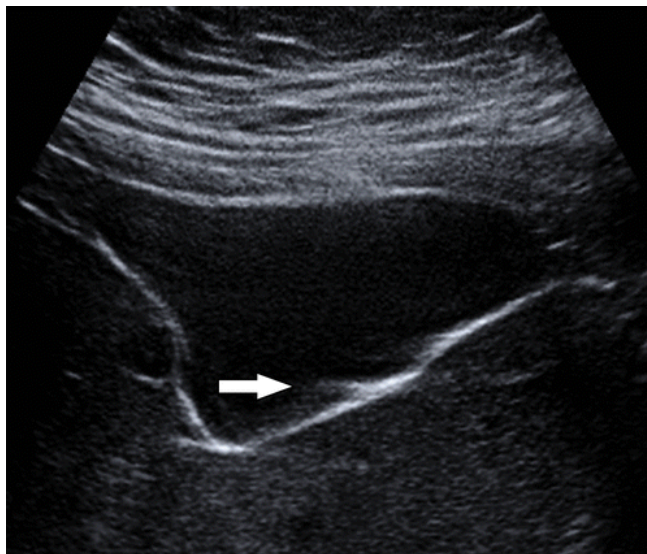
Image taken from Baad M. et al. RadioGraphics 2017 37(5):1408-23
